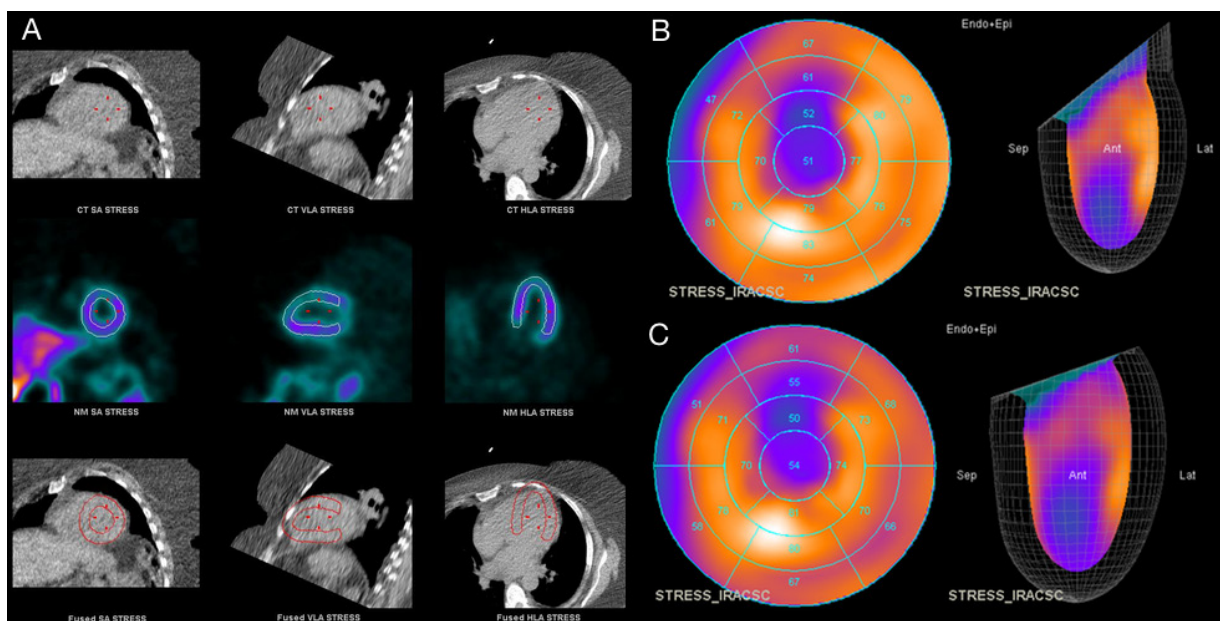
Stress myocardial perfusion SPECT/CT study showing (A) misregistration of SPECT and CT data that results in (B) a small apical defect. (C) Once the misregistration is corrected, the severity and extent of the apical defect changes.
